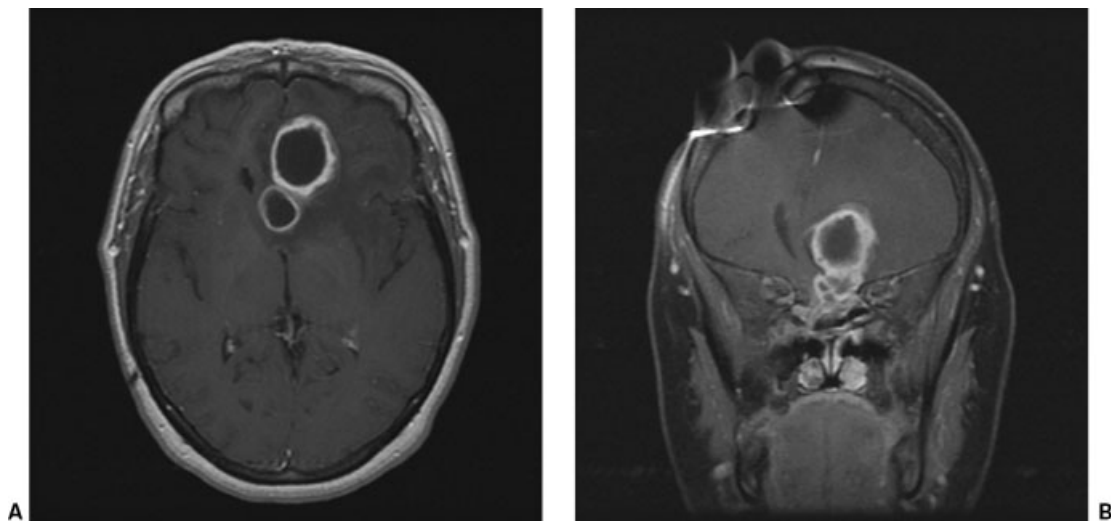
Postoperative (1.5 years) (A) axial and (B) coronal T1-weighted MRIs show a 5.3×3.1 -cm multilocular, ring-enhancing, cystic mass in the medial aspect of the left frontal lobe with surrounding edema.
